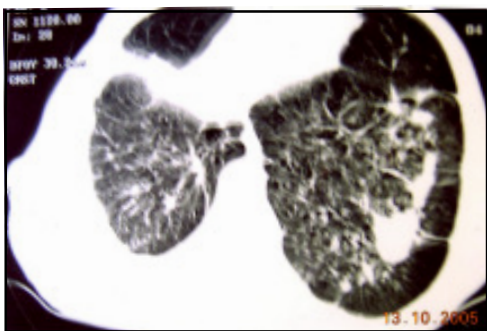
HRCT of chest showing reticulo-nodular pattern on both sides.
